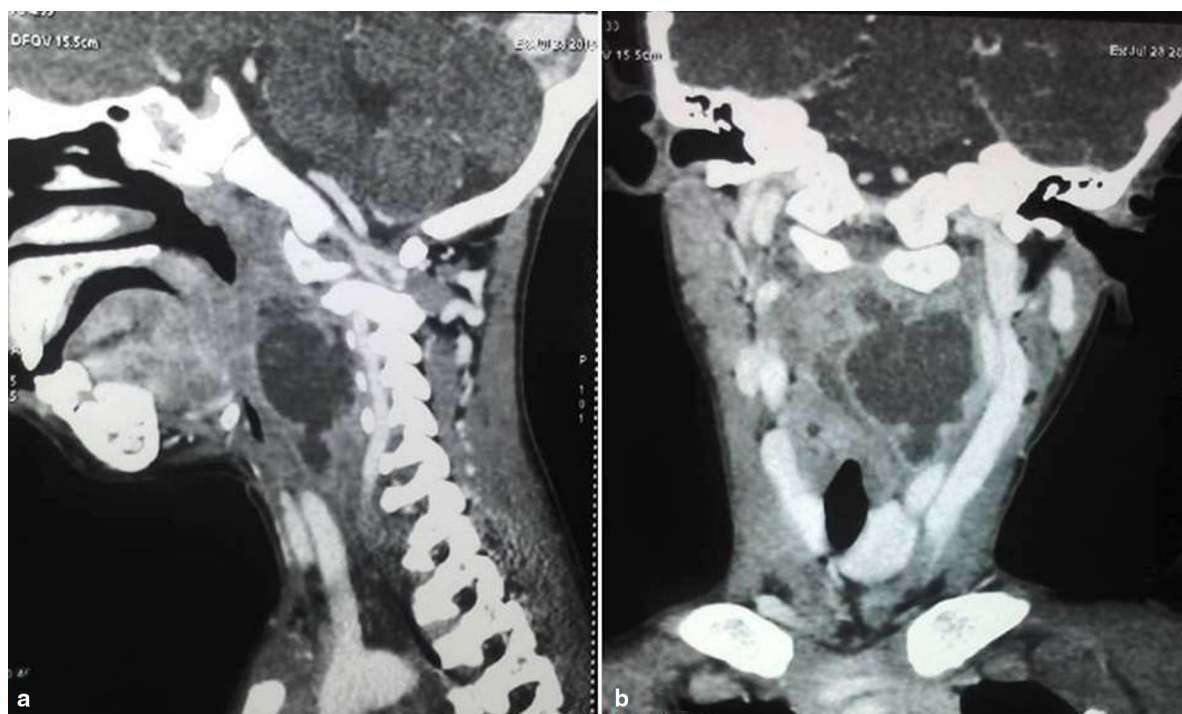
CT scan of the neck showing retropharyngeal abscess obstructing the supraglottic airway. a) lateral view, b) A-P view
